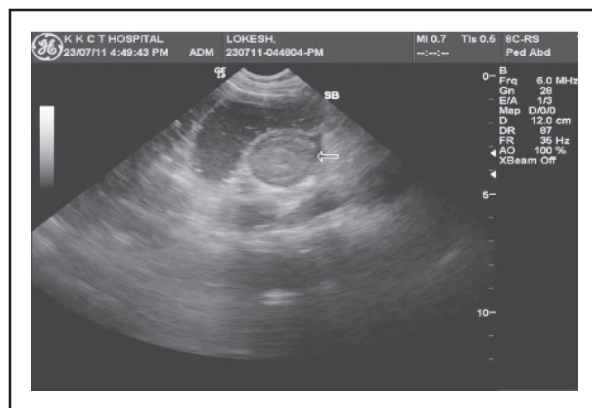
Ultrasound of abdomen showing target sign of intussusception
